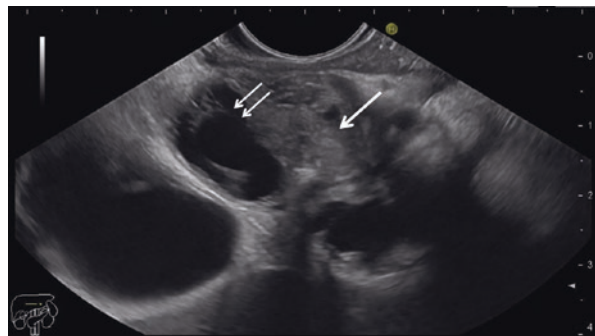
EUS-guided FNA. A 22 gauge needle (arrow) is advanced into a pancreatic cystic lesion through the gastric wall under real-time ultrasound guidance in order to obtain a cystic fluid sample
